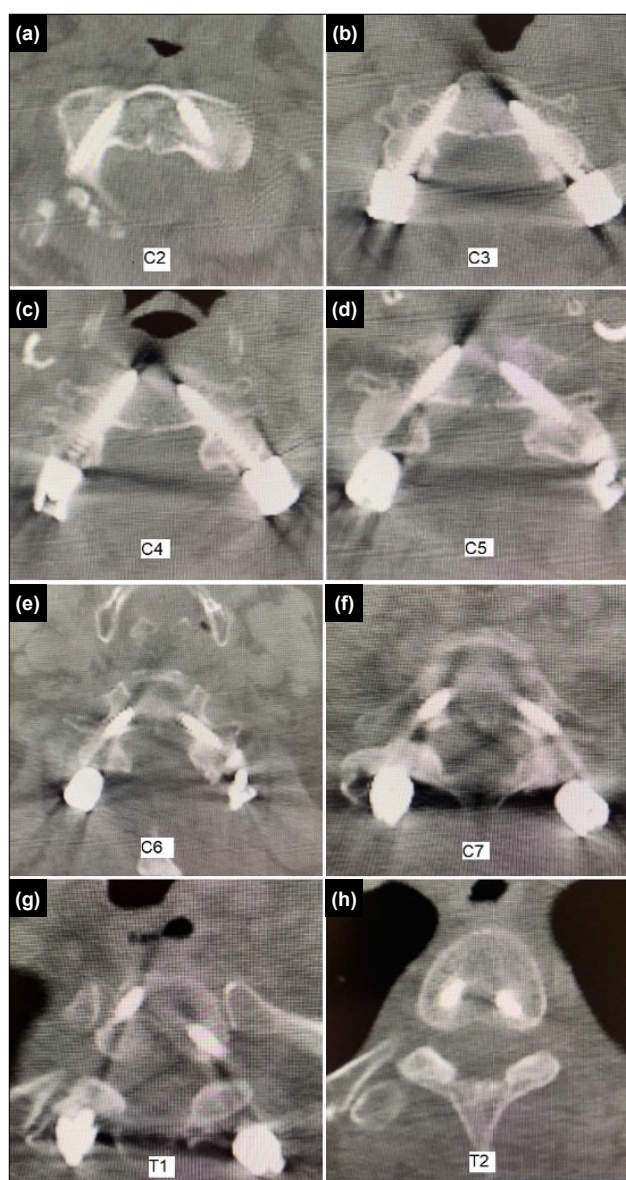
(a-h) Postoperative axial computed tomography (CT) images from C2 to T2.
